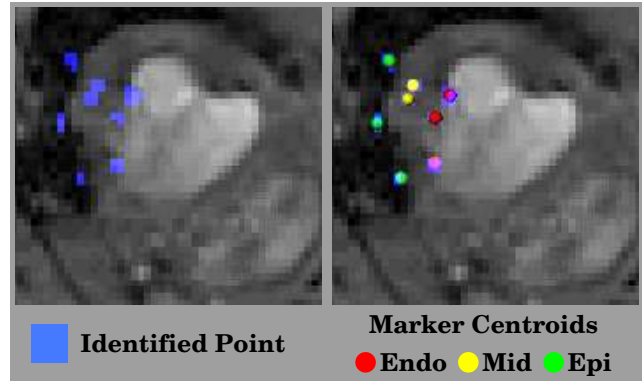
Localization of implanted markers. Arrays consisting of 12 markers each were placed at two positions on the left ventricle. In this figure, we show the portion of one marker array as it intersected a short-axis MR image slice. A human observer identified the pixels corresponding to each marker (left) and the marker positions (right) were found by calculating centroids of these points.
